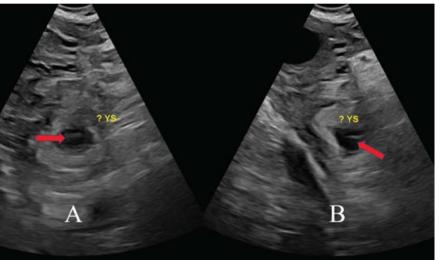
Longitudinal transvaginal ultrasound of the rig adnexa demonstrates a thick walled hypoechoic cysti structure (red arrow) with weak peripheral vascularity ("ring of fire"). There is no fetal pole present
